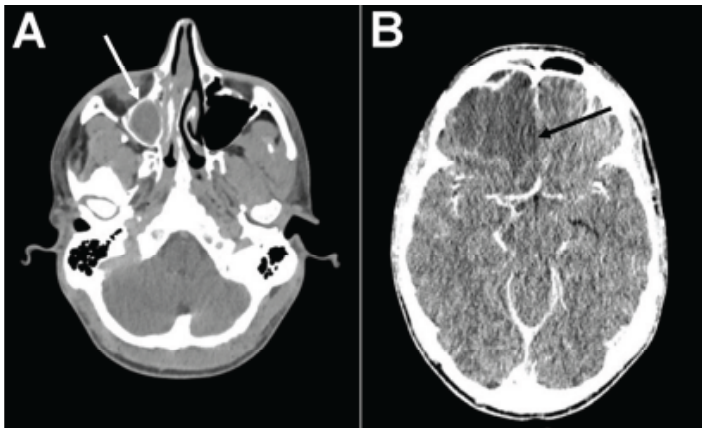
Head computed tomography without (A) and with (B) intravenous contrast. Imaging demonstrated a complicated right frontal sinusitis (white arrow) with intracranial extension and formation of an abscess with extensive associated vasogenic edema and mass effect with two-millimeter leftward midline shift (black arrow).
